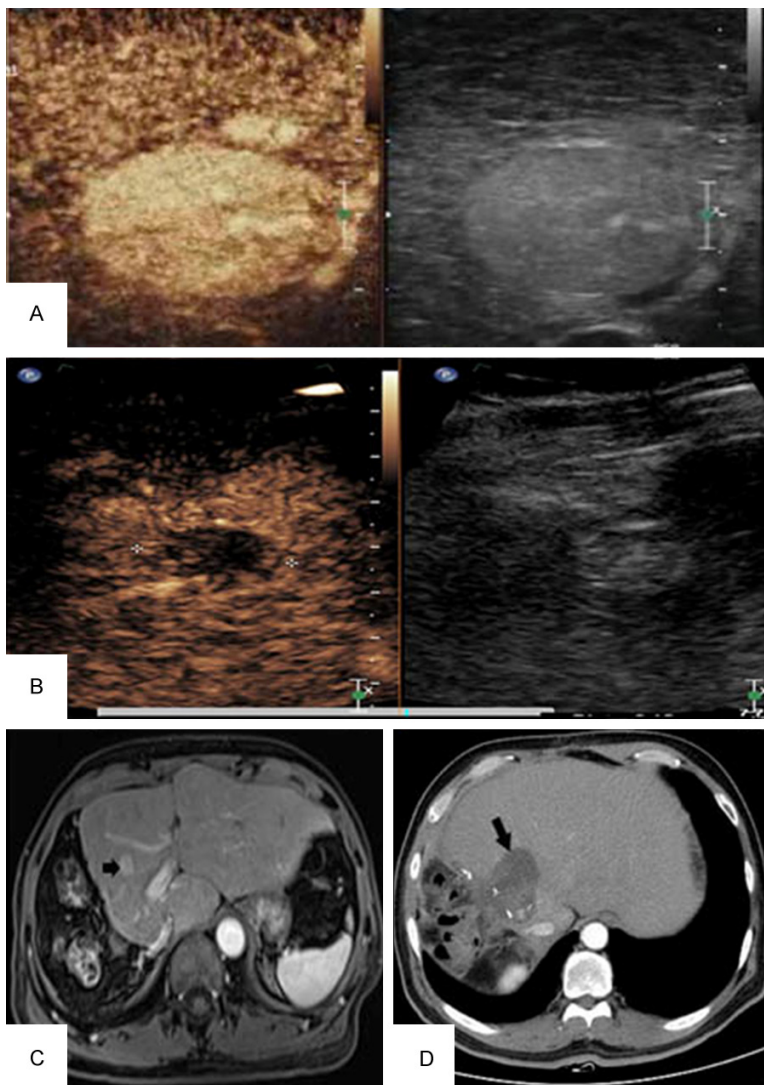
A. Hyperenhancement in arterial phase indicating HCC nodule on CE-IIOUS before RFA; B. Hypoenhancement in arterial phase indicating ablated HCC nodule on CE-IIOUS after RFA; C. Contrast enhanced CT shows HCC nodule (arrow) in arterial phase; D. Complete ablated region (arrow) 1 month after RFA on contrast enhanced CT during follow-up period.
